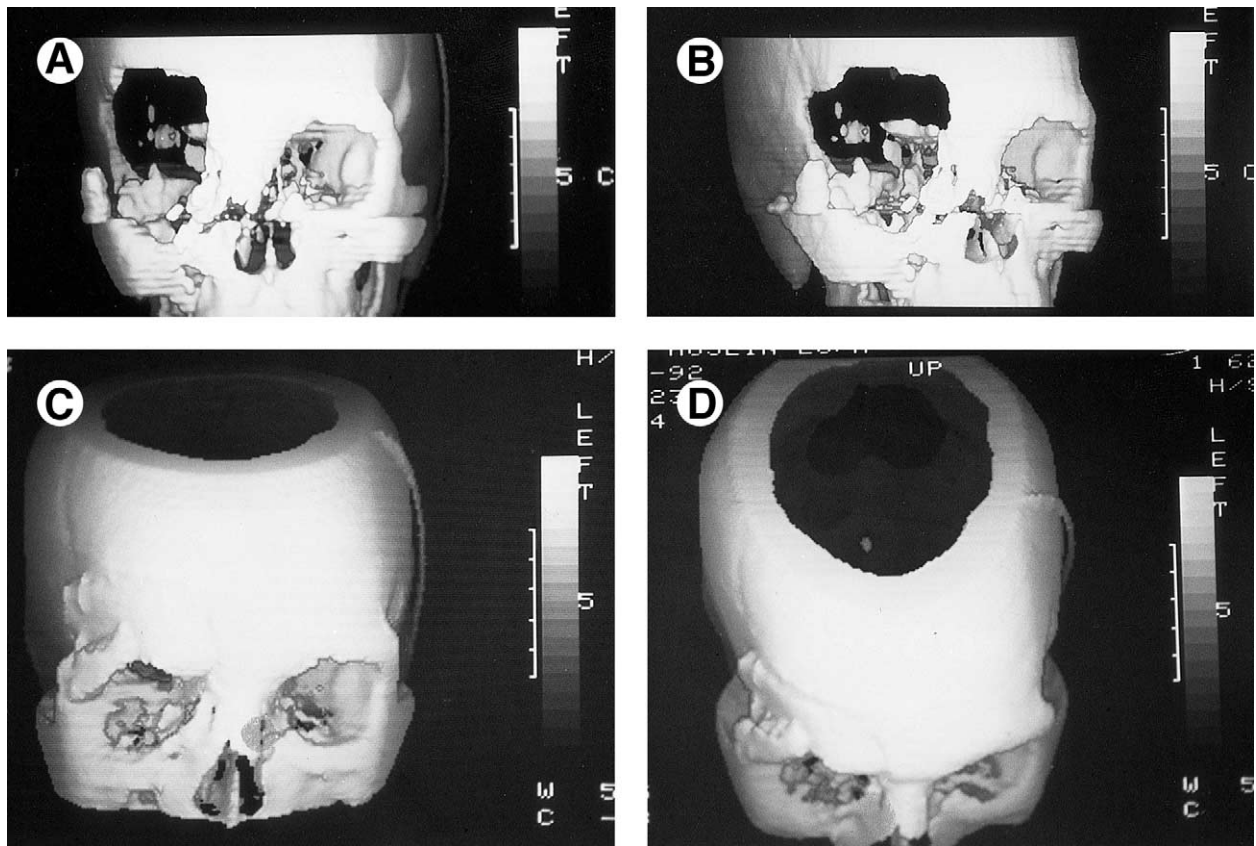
Three-dimensional computed tomography scan of an extensive high-velocity bullet wound exiting the right orbit and anterior skull. A, B, Note the amount of damage that may be inflicted by high-velocity projectiles. C, D, After neurosurgery, reconstruction of the hard tissues was done with iliac bone grafts.
